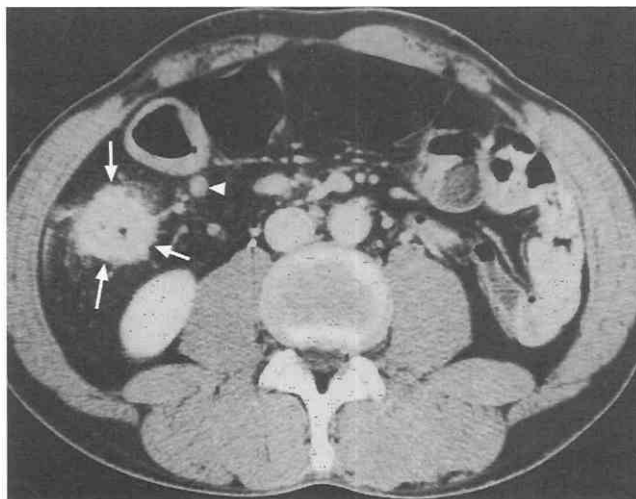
Tuberculous colitis. CT scan shows concentric bowel wall thickening (arrows) of the ascending colon with pericolonic stranding and minimal lymphadenopathy (arrow-head).
